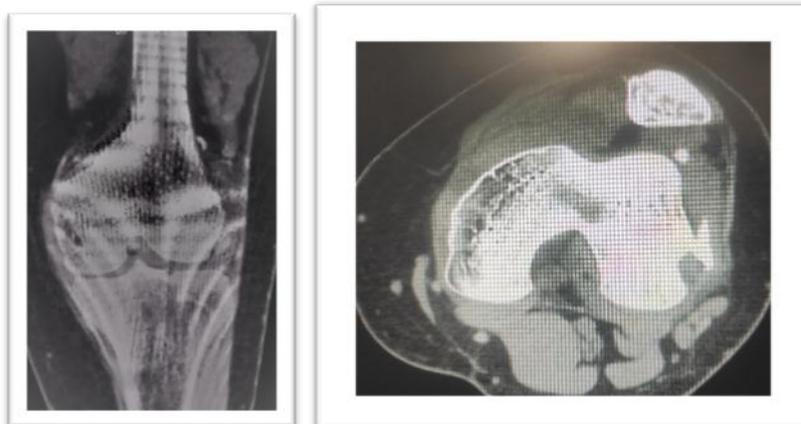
CT images showing an osteochondral fragment associated with a dislocated patella.
